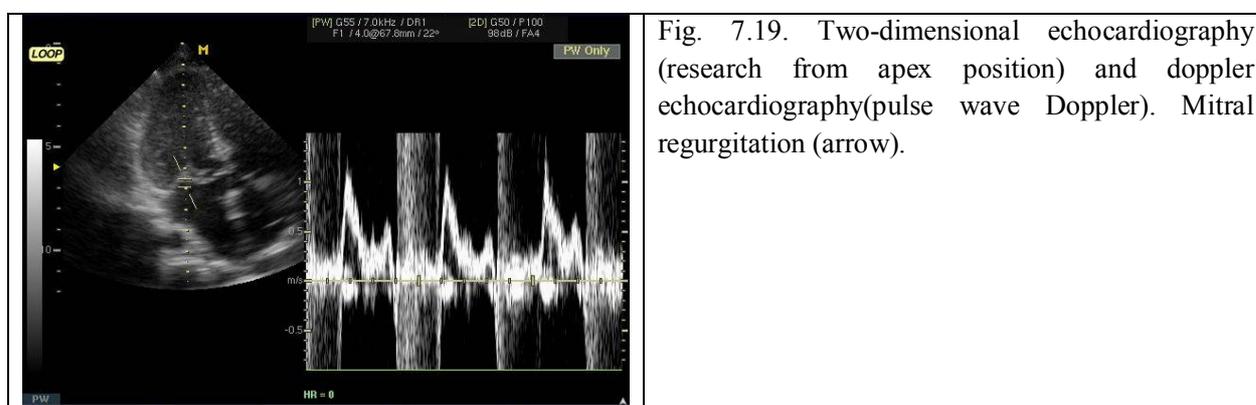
Two-dimensional echocardiography (research from apex position) and doppler echocardiography(pulse wave Doppler). Mitral regurgitation (arrow).
